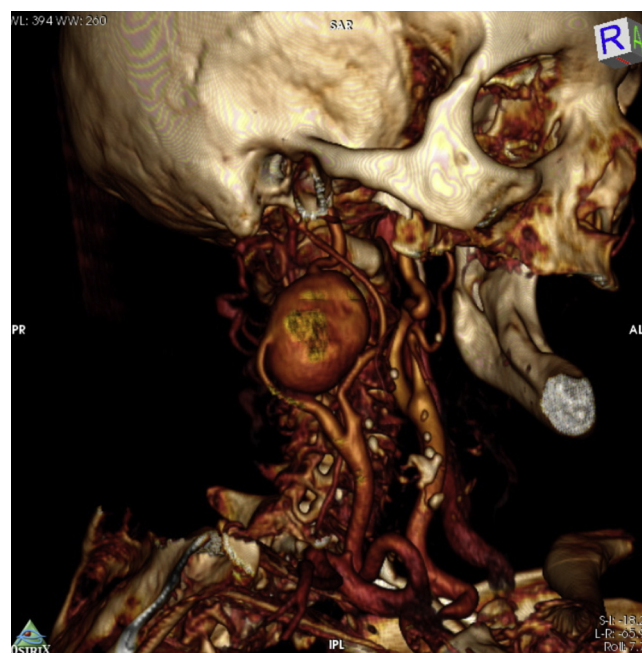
Computed tomography: with right internal carotid fusiform aneurysm and the extremely tortuous of the common carotid artery.
